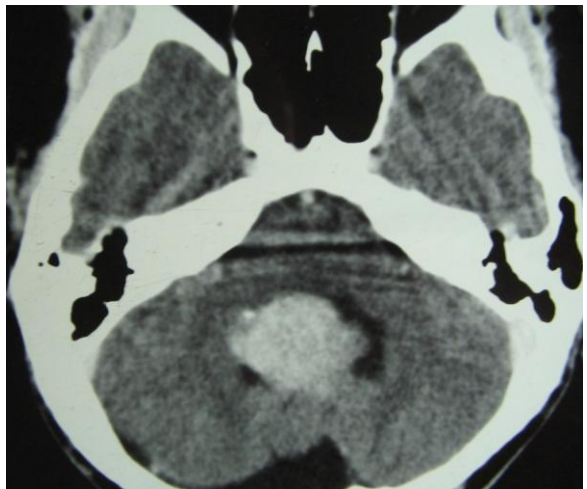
CT head (plain) of one of our patient showing a hyperdense vermian lesion.
